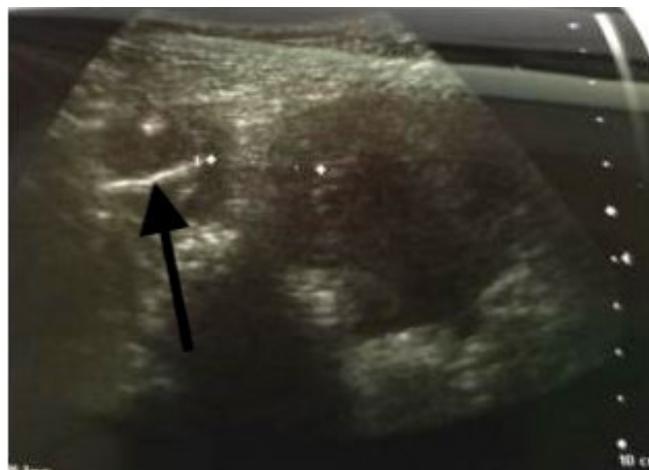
Abdominal ultrasound. The arrow shows a suspected IUD, but its actual location cannot be determined
